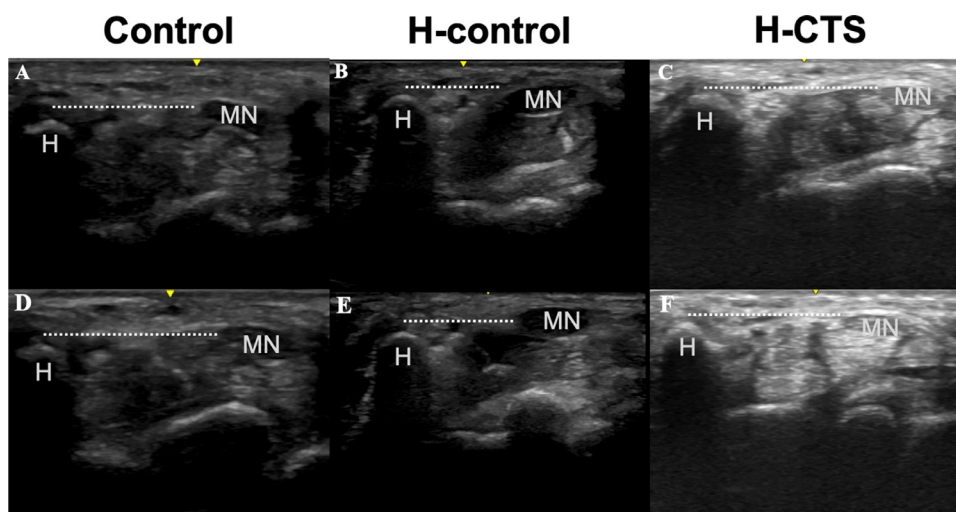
Ultrasonography evaluation of the distance between the tip of the hamate hook and the ulnar edge of the rMHD (A-C) and the gMHD (D-F) in control, H-Control, and H-CTS groups, respectively. The RMHD is defined as $gMHD - rMHD / rMHD$. Abbreviations: H, hamate hook; MN, median nerve.
